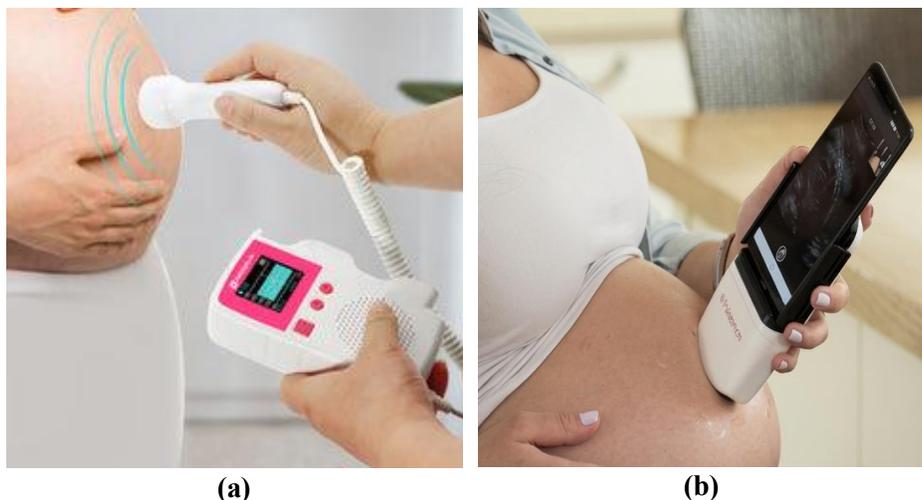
Commercial handheld devices: (a) FetalPlus fetal doppler [80] and (b) Pulsionmore ultrasound [81].
